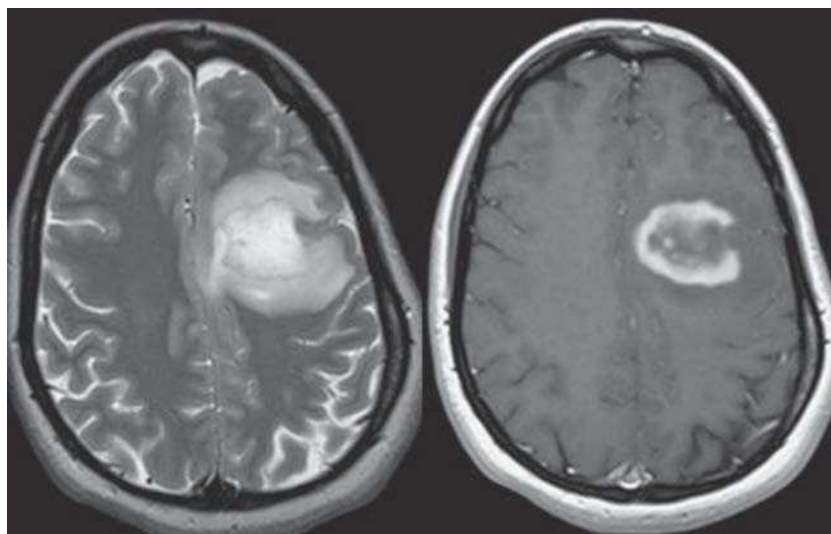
Brain magnetic resonance imaging. T2-weighted sequences (left) and contrast T1 (right) in the transverse plane in a patient with a pseudo-tumoral lesion of demyelinating origin. Note that the lesion shows an incomplete ring enhancement with its open margin in contact with the cortical grey matter (courtesy of Dr. Marzo).
